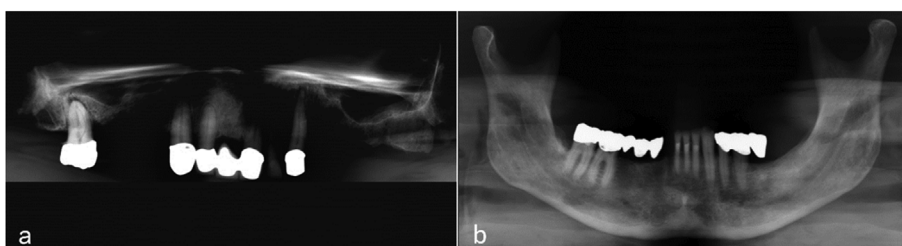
Post-mortem panoramic radiographs.
